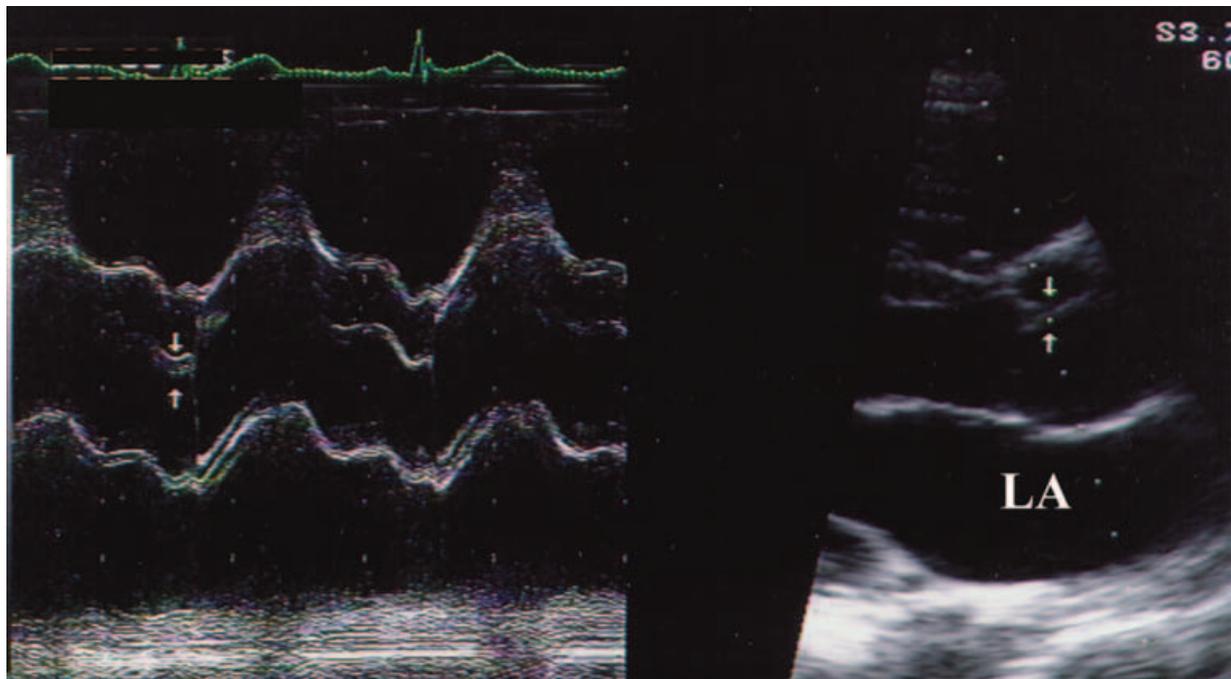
M-mode and two-dimensional (2D) diastolic frame in the parasternal long-axis view of a bicuspid aortic valve with eccentric closure (arrows). Although not diagnostic, an eccentric line of closure should prompt one to evaluate the aortic valve closely for BAV. LA = left atrium. (Modified with permission from: Kerut EK, McIlwain, Plotnick: *Handbook of Echo-Doppler Interpretation 2nd Ed*, Blackwell Publishing, Elmsford, New York, 2004, p. 84)
